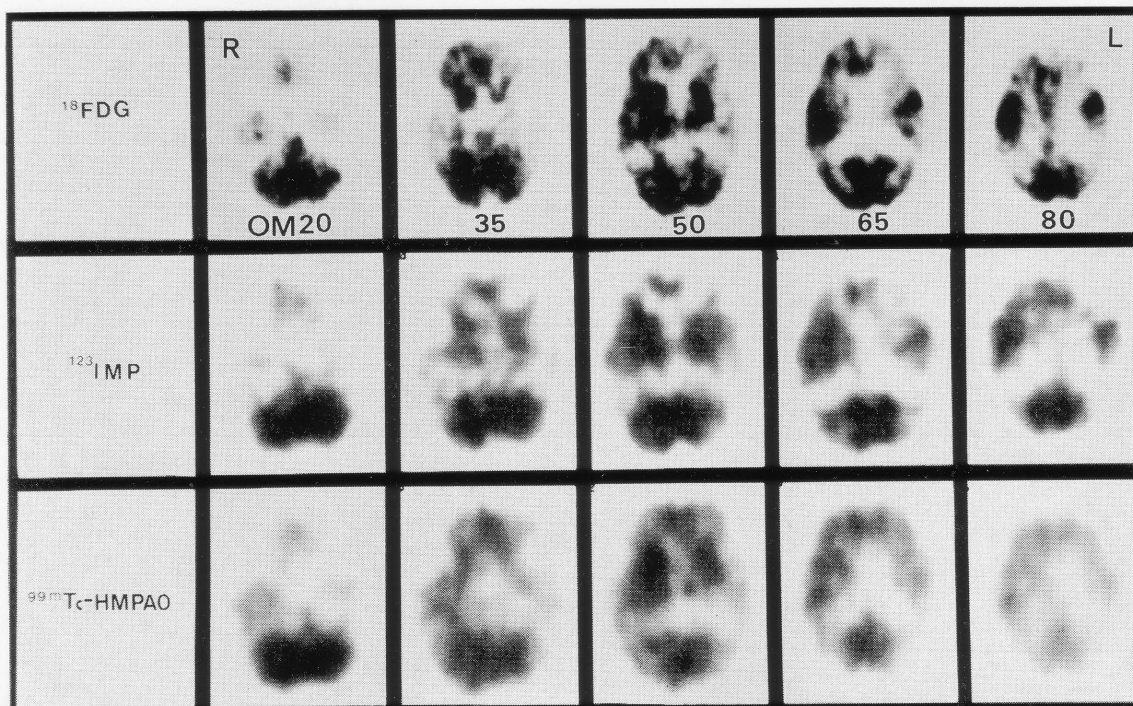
(Alzheimer's disease, 61-year-old male) (F-18 FDG PET, I-123 IMP SPECT and Tc-99m HMPAO SPECT images show decreased CMRGlc and perfusion in the fronto-temporo-parietal regions on both sides. The cerebellum, striatum, primary visual and motor cortices are relatively spared. HMPAO SPECT images show less contrast than I-123 IMP SPECT.
